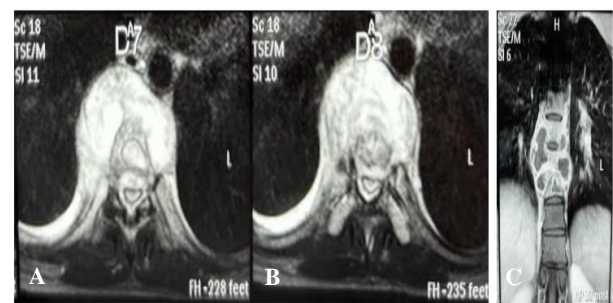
(A-C): MRI axial and coronal cuts show evidence of anteriorly and laterally placed abscess with vertebral destruction and collection from T7 to T10 levels.
